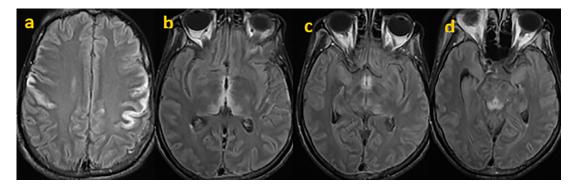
Axial sections of MRI in FLAIR sequence: signal abnormalities on parietal cortex (a), in, medial thalamus (b), in periaqueductal area and the mammillary bodies (c, d).
